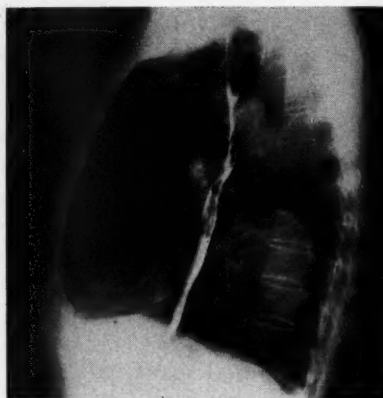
Roentgenogram showing uncommon saccular arteriosclerotic aortic aneurysm just above the diaphragm.
